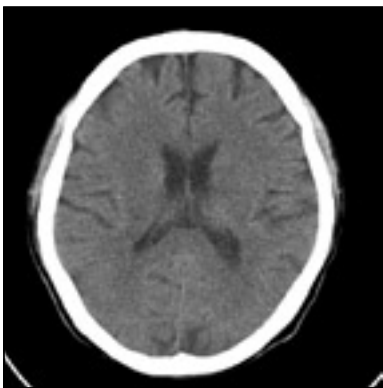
Axial plain computed tomography of the brain showing bilateral hypodense lesions in the parieto-occipital region
